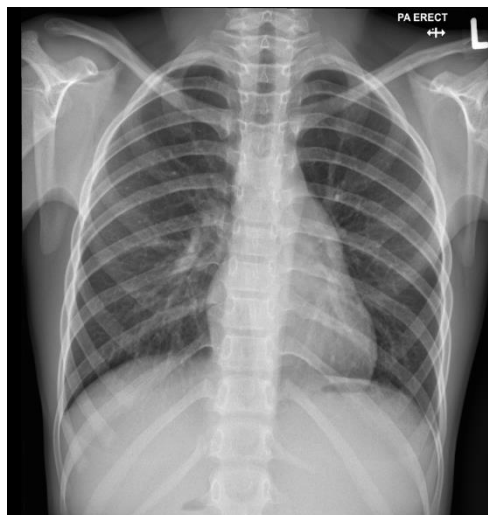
Chest x-ray of MHI taken at diagnosis.
